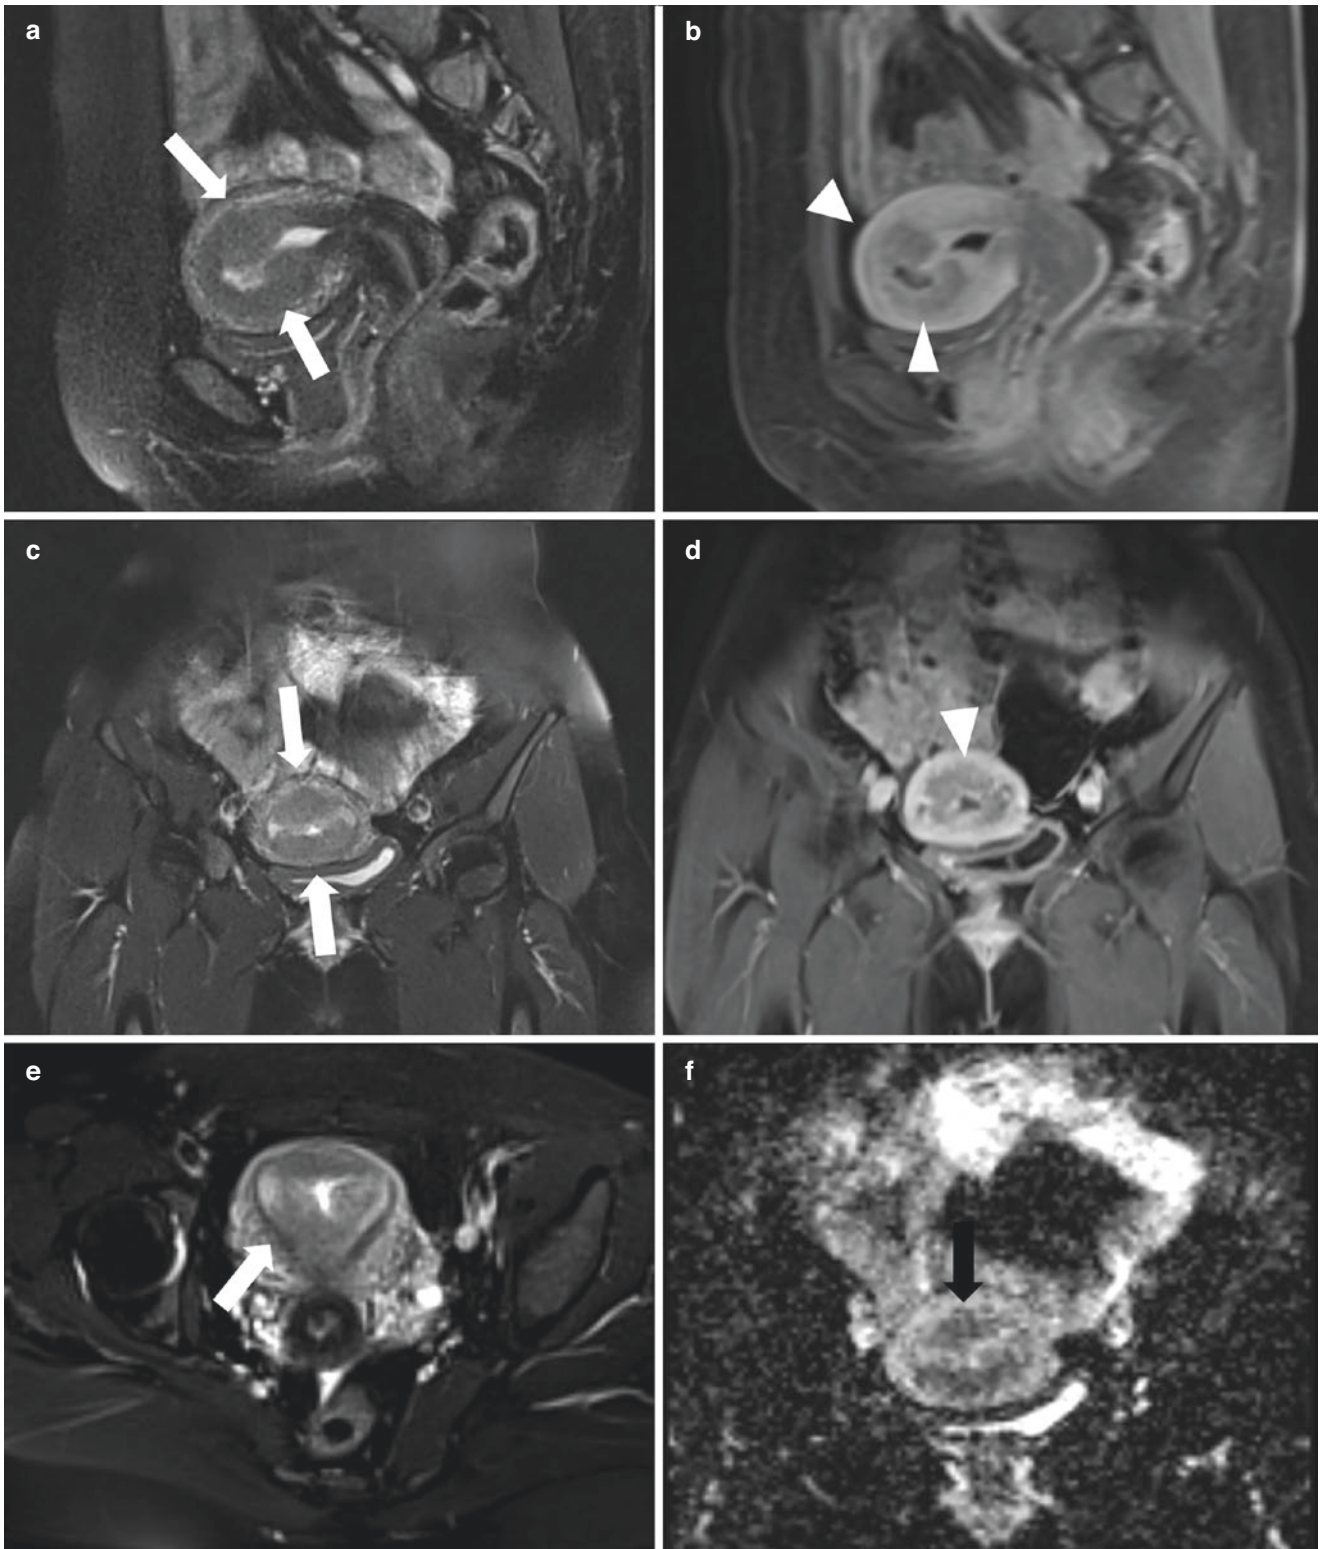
Endometrial carcinoma with deep myometrial invasion in a 38-year-old woman. (a) Sagittal T2WI images with fat suppression and two T2-weighted sequences angled perpendicularly of the uterus (c, e) showed a thickened junctional zone of uterus. No obvious intrauterine mass was observed. (b, d) Sagittal and coronal contrast-enhanced T1WI images showed relatively low signal intensity in myometrium. (f)
